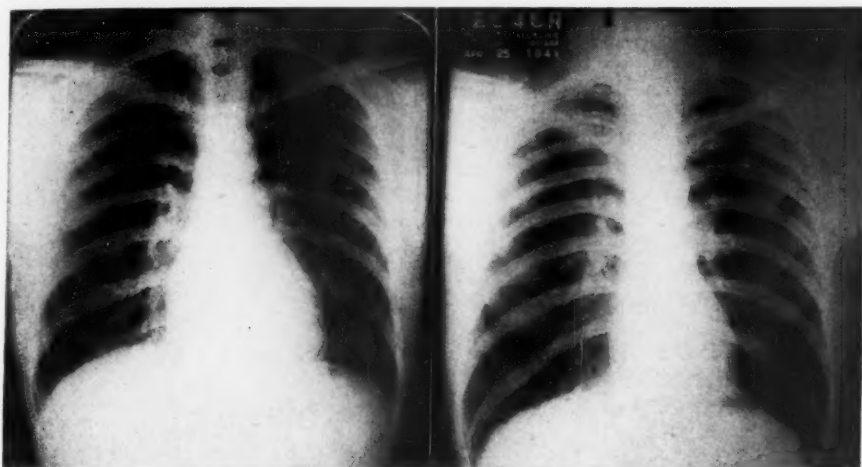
A. Chest roentgenogram taken before operation. Area of heart and great vessels 180 sq. cm. B. Chest roentgenogram taken three years after closure of the fistula. Area of heart and great vessels 135 sq. cm.
